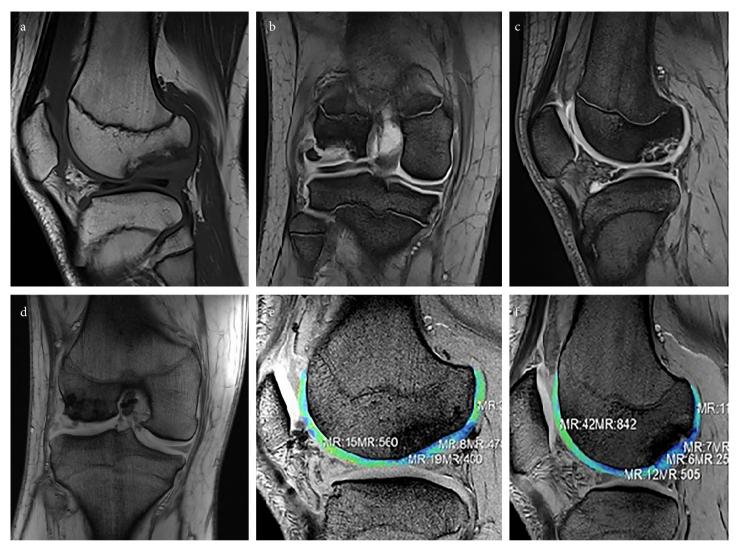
a-f. A 16-year-old male patient withOCD. Irregularity in the joint surface at the femoral lateral condyle with sagittal proton density image, and an irregular area with low signal intensity (a). Irregularity at the cartilage surface at the femoral lateral condyle and approximate osseous fragment displaced laterally on the coronal and sagittal T2-weighted images (b, c). Postoperative first-year coronal MRI (d). Postoperative second-year (e). Postoperative fifth-year cartilage thicknesses on STIR MRI (f)
